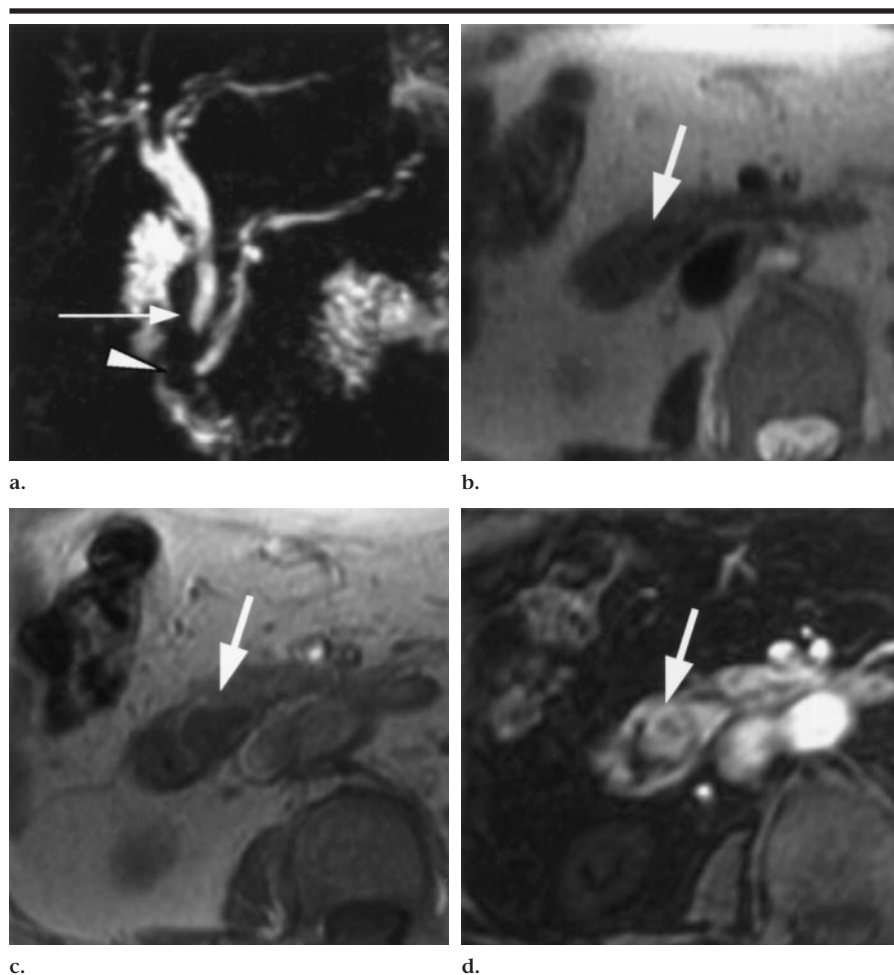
Surgically proved ampullary carcinoma in a 71-year-old woman. (a) Coronal maximum intensity projection image reconstructed from MRCP images (fast SE, 13,200/252) shows mild dilatation of the common bile duct (arrow) and pancreatic duct with short segmental interruption of the ampulla (arrowhead). (b) Transverse less heavily T2-weighted image (fast SE, 10,909/120) and (c) transverse precontrast in-phase GRE image (140/4.2) show soft-tissue signal intensity at the ampullary portion (arrow), but characterization of the lesion is difficult. (d) Transverse postcontrast three-dimensional GRE image (6.9/2.2/31; flip angle, 15°) more clearly demonstrates the focally bulging ampullary mass (arrow), but the differentiation between benignity and malignancy is difficult.
